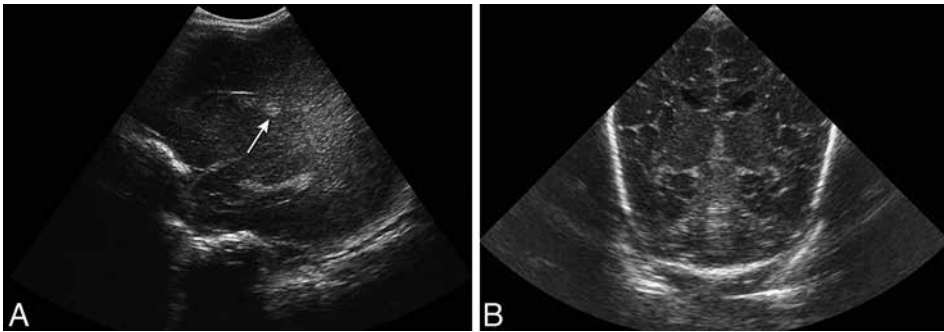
(A) Parasagittal ultrasound scan in very preterm infant (gestational age 30 wk) with Gram-negative sepsis, showing round echogenic lesion (arrow) in the periventricular area, representing beginning abscess formation. (B) Coronal ultrasound scan in very preterm infant (gestational age 26 wk) with disseminated *Candida* infection, showing multiple small echogenic lesions, representing micro abscesses.
